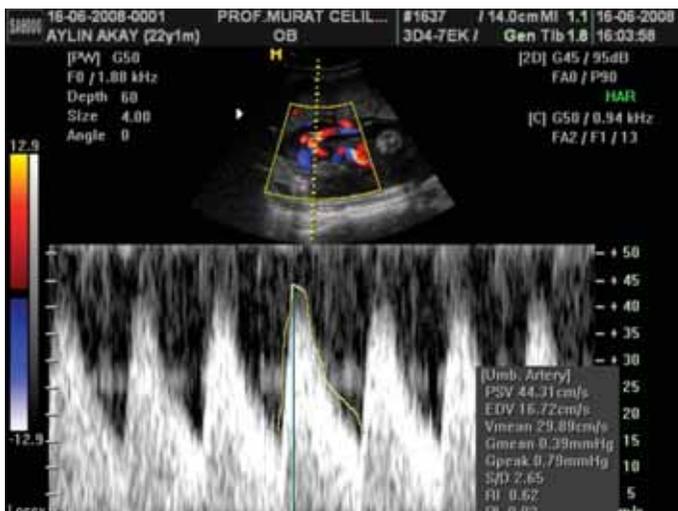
Doppler indexes of umbilical artery
